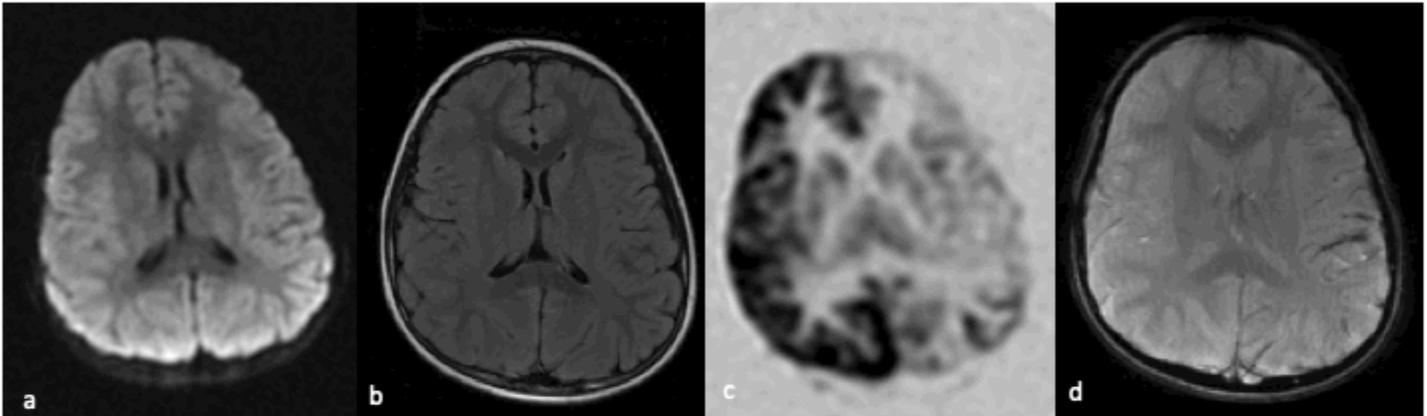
STROKE MIMIC : migraine with aura. Clinical history-15 year old with right hemiplegia and headaches. Imaging-rapid stroke protocol MRI showing a) DWI- no restricted diffusion b) axial T2 flair – no abnormal signal alteration c) ASL with hypoperfusion pattern involving the left cerebral hemisphere and d) SWI - prominent hypointense signals of the venous vasculature within areas of impaired perfusion.
